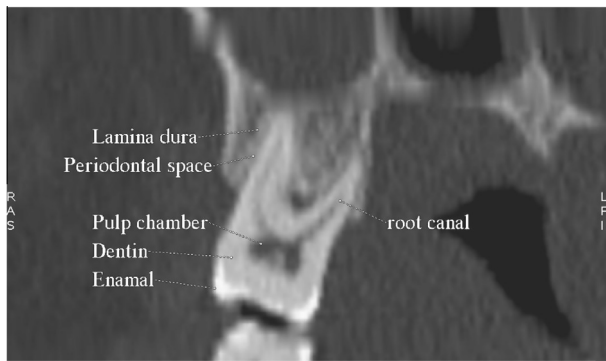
Normal CT anatomy of a maxillary molar tooth. Diseased maxillary sinus is seen.
